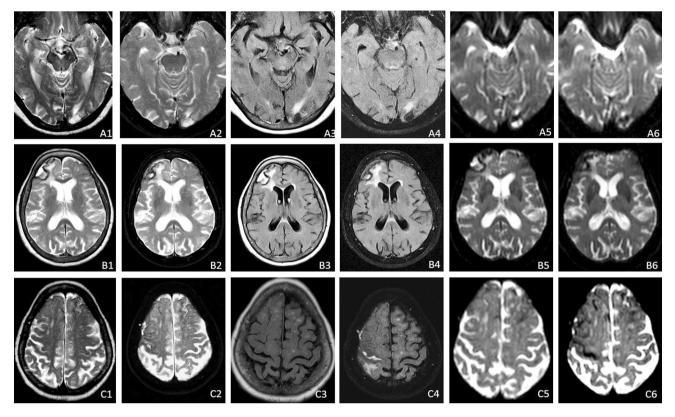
The MR showed areas of pathologic signal, in left occipital lobe, suggestive of hemorrhage (a1–a2 axial T2W; a3, a4 FLAIR W; a5–a6 ADC map images), in *right frontal lobe*, in different phases
